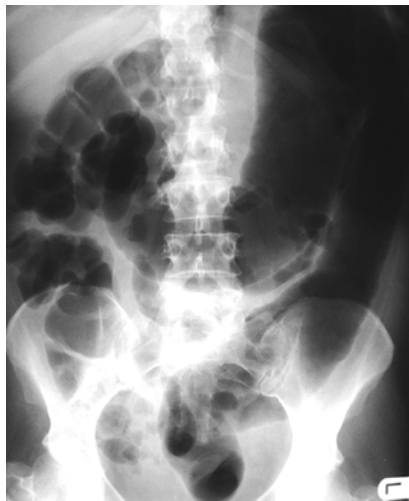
Plain Abdominal X-ray of toxic megacolon.
